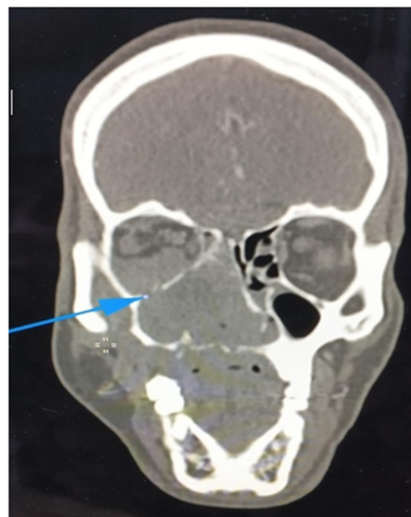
(A, B): Contrast-enhanced CT of the paranasal sinuses and skull base.
